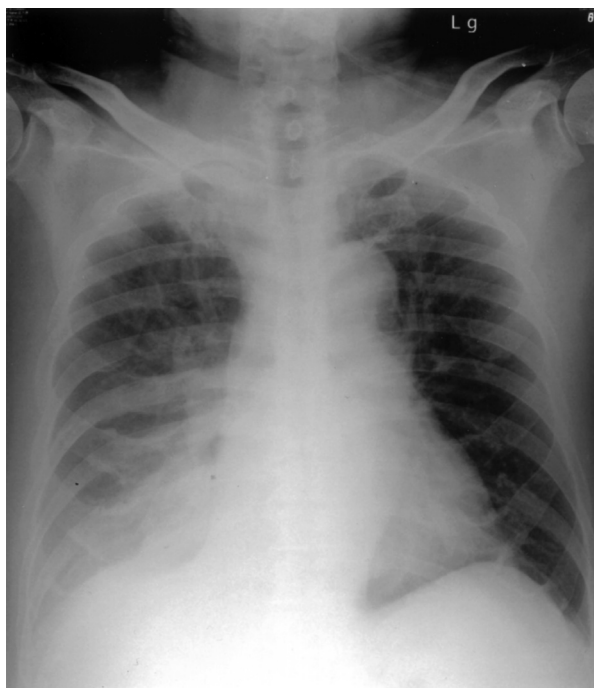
Chest radiography, posteroanterior view, shows right lower increased infiltrates and pleural effusion (case 1)
